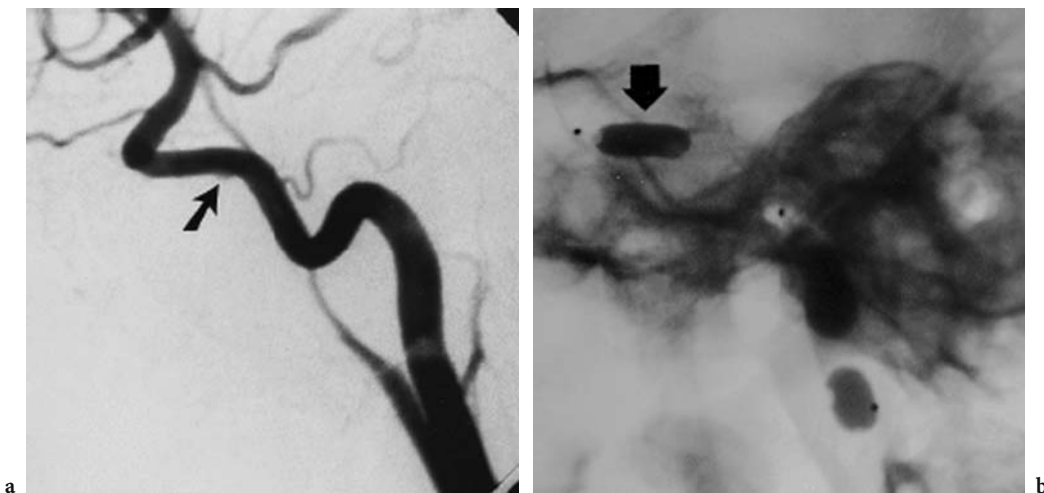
a Right common carotid artery angiogram shows a subtle pseudoaneurysm of the cavernous internal carotid artery (ICA) (*arrow*). b Lateral radiograph shows three detachable balloons used in permanent balloon occlusion of the right ICA. The most distal balloon covers the orifice of the pseudoaneurysm (*arrow*)
